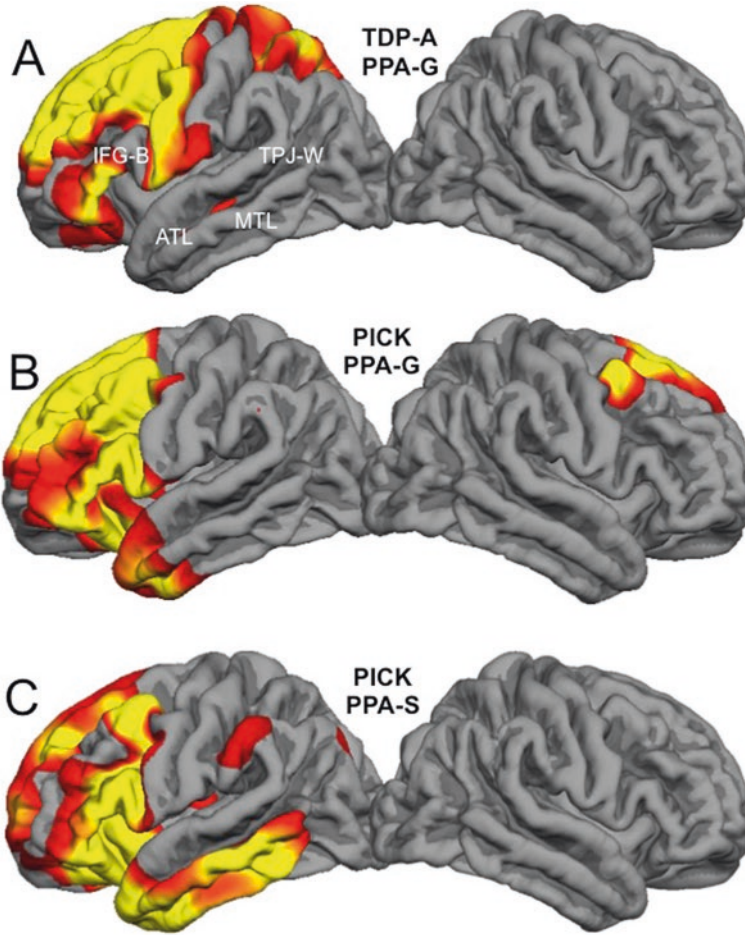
Correspondences of pathology, atrophy, and syndrome. Quantitative MRI morphometry in three right-handed patients who had come to postmortem brain autopsy. Areas of significant cortical thinning compared to controls are shown in red and yellow. (a) Onset of PPA-G was at the age of 65. The scan was obtained 2 years after onset. At postmortem, the primary pathology was FTLD-TDP type A. (b) Onset of PP-G was at the age of 57. The scan was obtained 5 years after onset. At postmortem, the primary pathology was Pick's disease. (c) Onset
